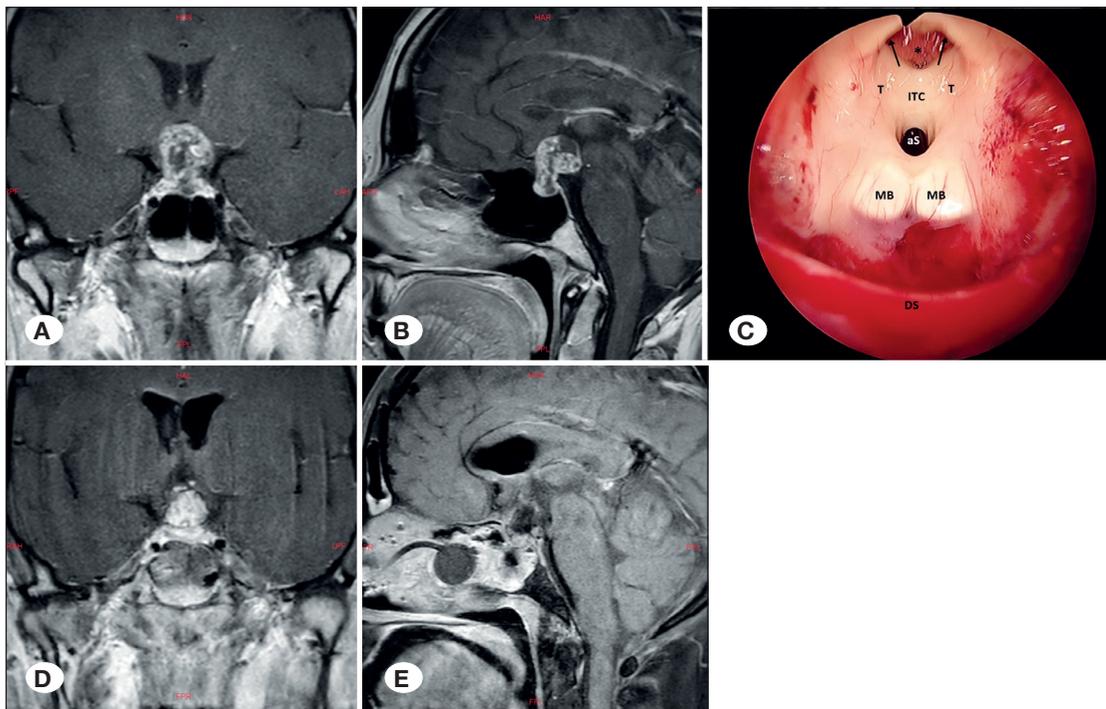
A 42-year-old female with Craniopharyngioma A, B) Preoperative T1-weighted contrast-enhanced coronal and sagittal MRI displaying a mass with heterogeneous contrast enhancement and areas of cystic degeneration measuring $23 \times 21 \times 22$ mm in the suprasellar region. C) Intraoperative view after total resection of the mass using an endoscopic transnasal transsphenoidal approach. Key structures are labeled, including T (thalamus), ITC (interthalamic commissure), aS (aqueduct of Sylvius), MB (mammillary body), DS (diaphragma sella), * (choroid plexus), and (arrow) foramen of Monro. D) Postoperative twenty-four hours, T1-weighted contrast-enhanced coronal MRI showing total resection of the mass and the appearance of fat grafts used for reconstruction. E) Postoperative twenty-four hours, fat-suppressed sequence sagittal MRI, displaying total resection of the mass.
